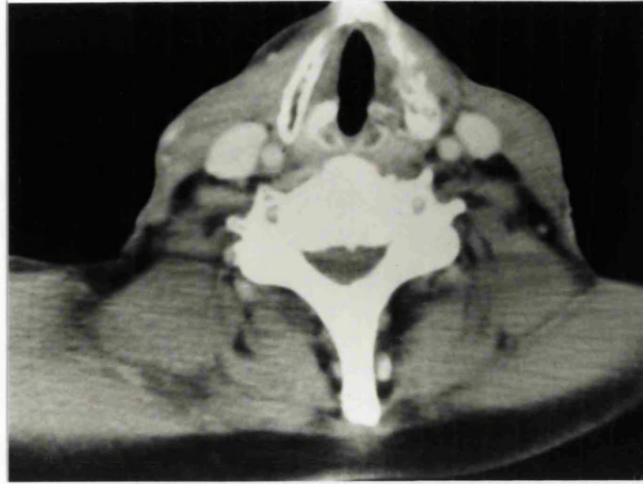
CT scan 3 months after radical-dose external beam radiotherapy showing possible radiation necrosis of the left thyroid cartilage but complete resolution of soft tissue mass.
